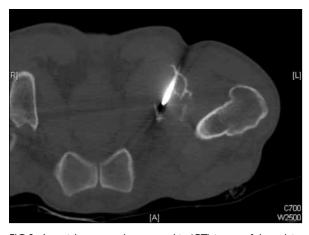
An axial computed tomographic (CT) image of the pelvis obtained during the procedure showing insertion of bone biopsy needle under CT guidance
